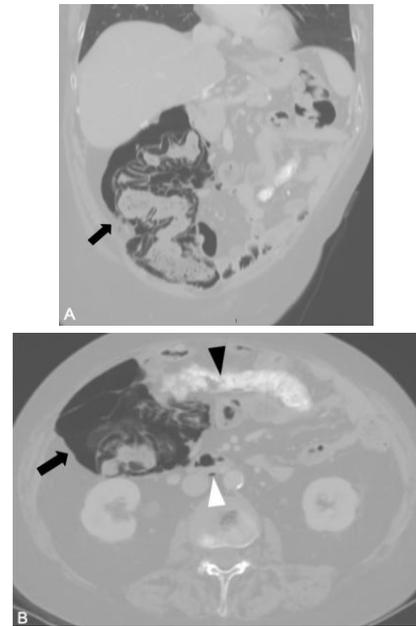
Coronal oblique multiplanar reconstruction and axial CT images from helical CT scan optimized with a large lung-size window scan in June 2019. Coronal CT reconstruction (A) highlighted the extent of colonic cystic wall pneumatosis, from the cecum to the proximal tract of the transverse colon (arrow). Axial CT scan (B) at the same level of the calcified peritoneal implant (black arrowhead), by applying a lung window, revealed a free retroperitoneal air bubble (white arrowhead) located between the abdominal aorta and the inferior vena cava.
